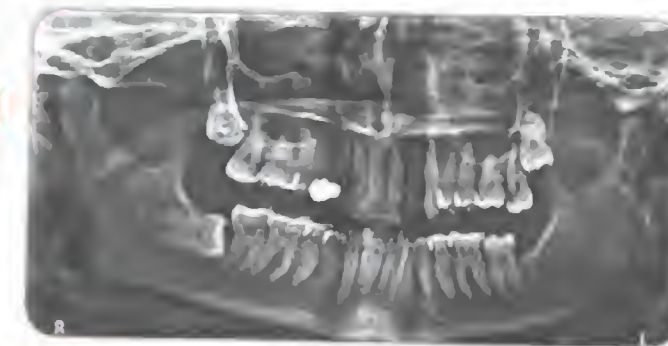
Orthopantomogram: Impacted molars
